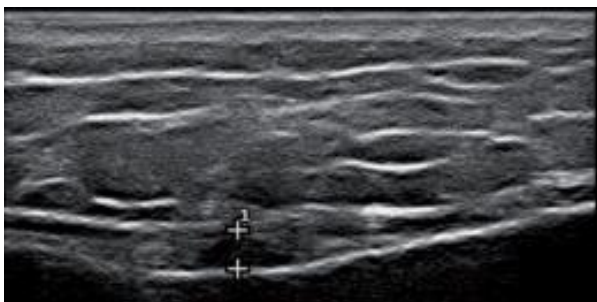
PAB with fluid accumulation as showed by the marked hypoechoic area. Retrived from: Toktas H, Dundar U, Adar S, Solak O, Ulasli AM. *Ultrasonographic assessment of pes anserinus tendon and pes anserinus tendinitis bursitis syndrome in patients with knee osteoarthritis. Mod Rheumatol. 2015 Jan;25(1):128-33.*
